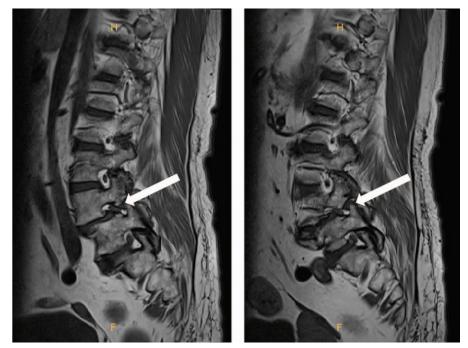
Preoperative T1-weighted magnetic resonance image of the lumbar spine showing L4-5 bilateral foraminal stenosis (arrow).
